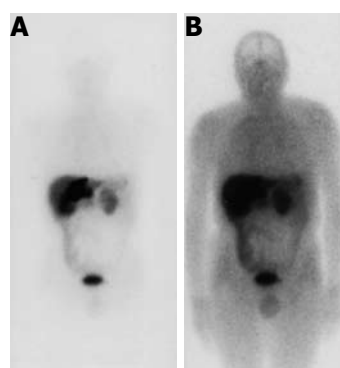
¹¹¹In-pentetreotide (octreotide) scintigraphy. A: Before hepatectomy: marked hyperactivity of the lesion is observed in the left hepatic lobe and interaortal adenopathy is observed; B: After hepatectomy; abnormal fluid accumulation of ligand in the epigastric region and dishomogeneous hepatic distribution.
